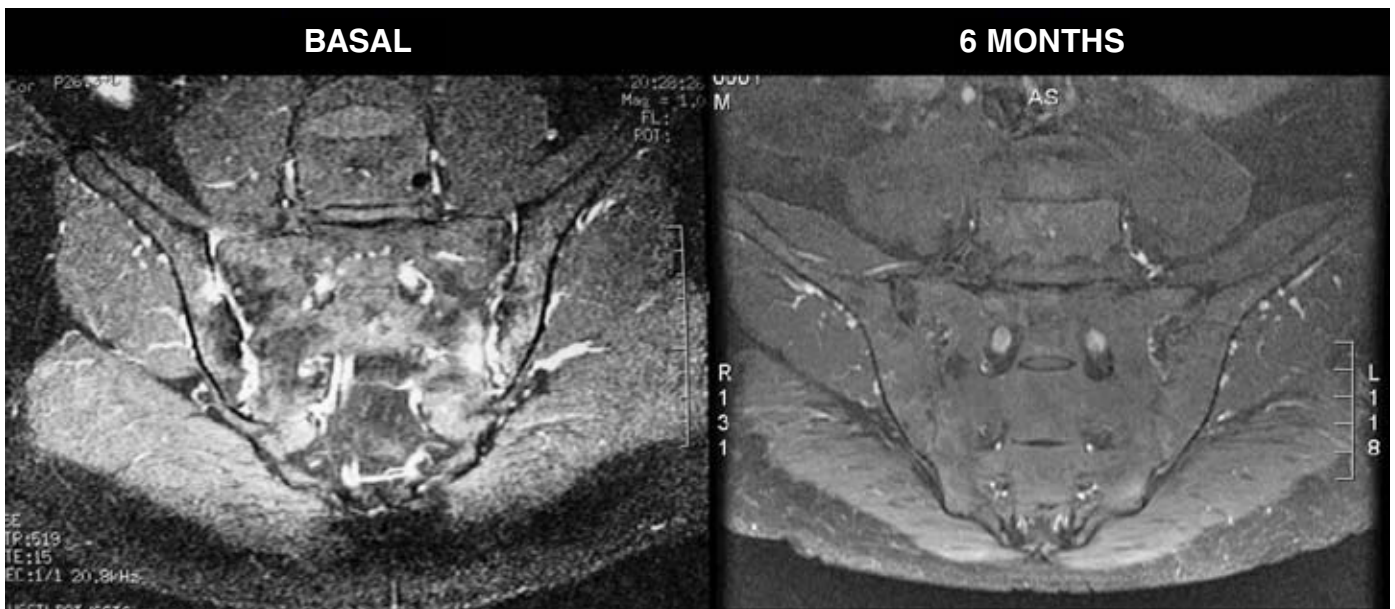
Response to treatment with adalimumab. Bilateral sacroiliitis seen in a magnetic resonance image which disappears after 6 months of treatment with adalimumab.
